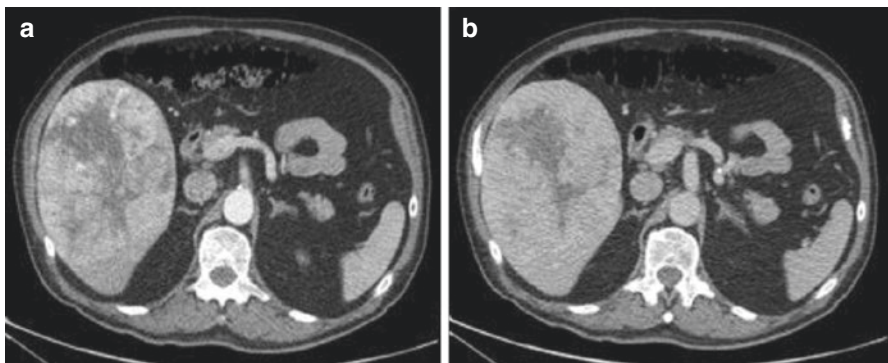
(a) Arterial phase CT showing a heterogeneous lesion with a necrotic centre. The periphery of the lesion enhances on the arterial phase. (b) Portal venous phase CT at the same level shows a washout of contrast *in keeping with features of HCC*
